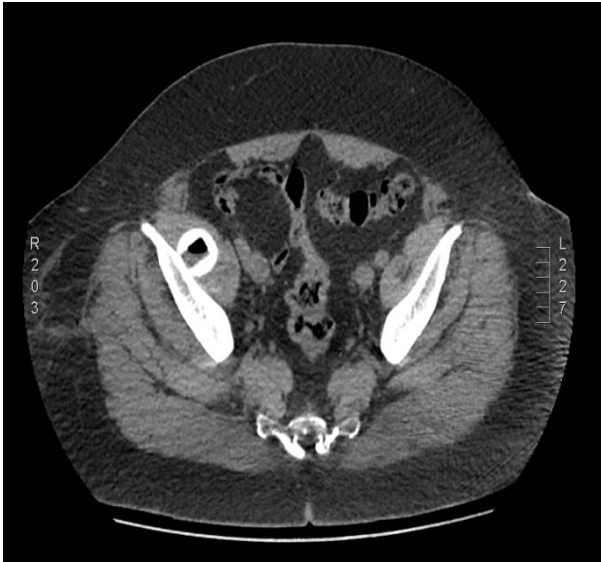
Axial CT scan section shows trial femoral head
